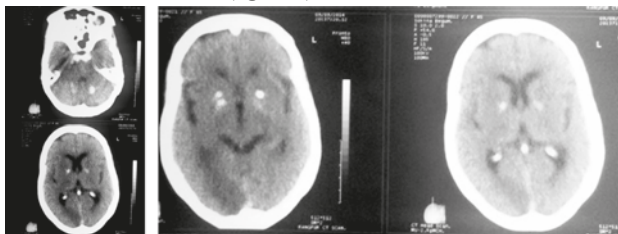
CT scan of brain
